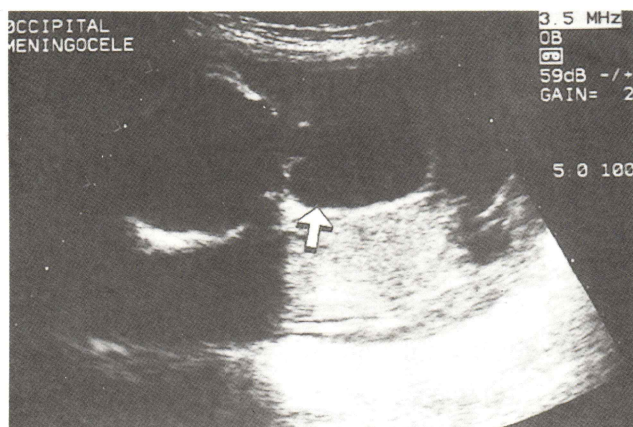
Ultrasound image of occipital meningocele.
